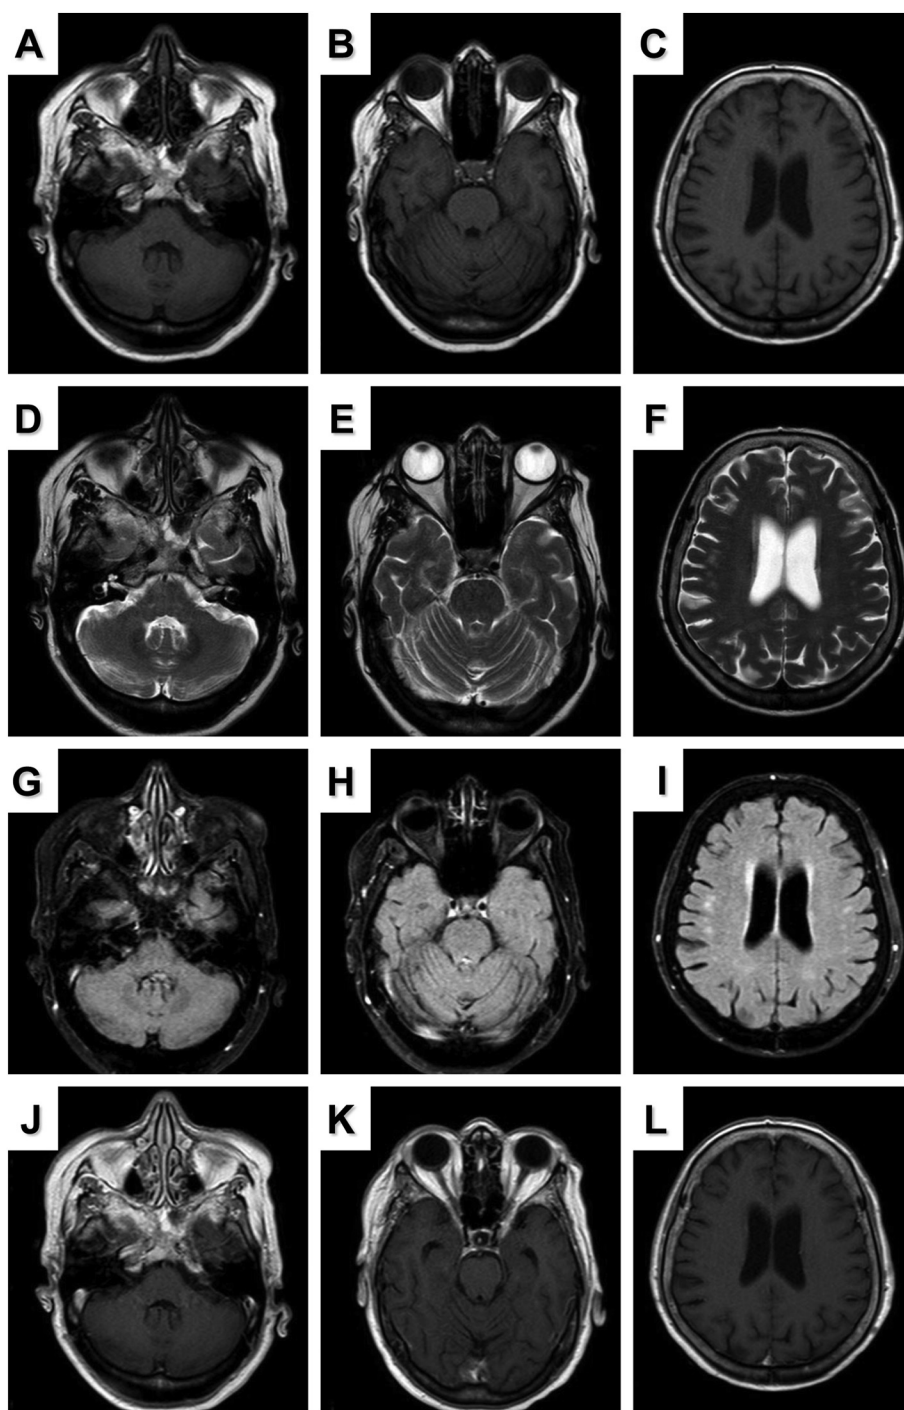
Patient 1. Axial T1 weighted (A–C), T2 weighted (D–F), Fluid attenuated inversion recovery - FLAIR (G–I) and T1 weighted with gadolinium contrast (J–L) MRI images showing only mild microangiopathic changes (F and I images).
